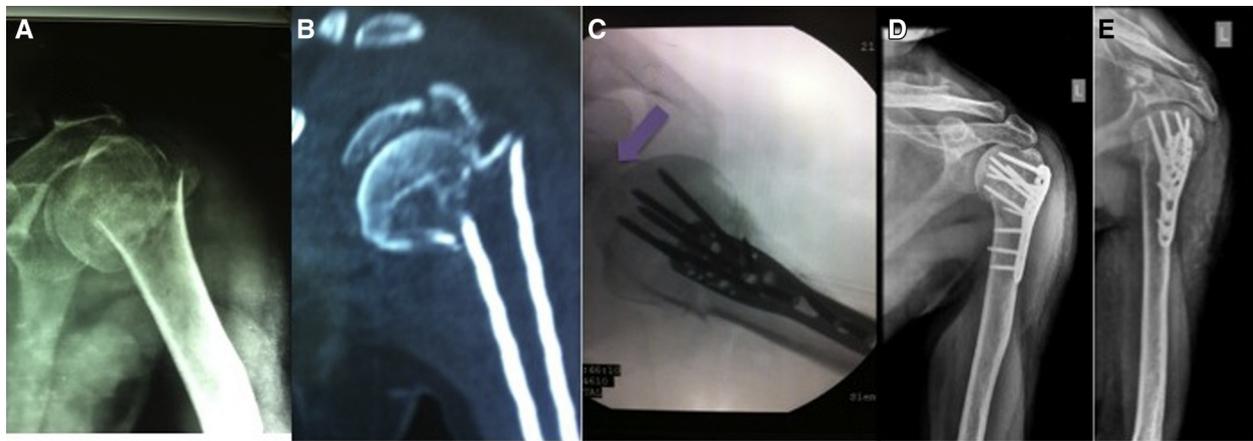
(A and B) Radiograph and CT image show a complex head-splitting fracture. (C) Intraoperative fluoroscopy image shows a satisfactory reduction of the split humeral head (*arrow*). (D and E) At 2-year follow-up, radiographs show union, maintenance of reduction, and a vascular head.
